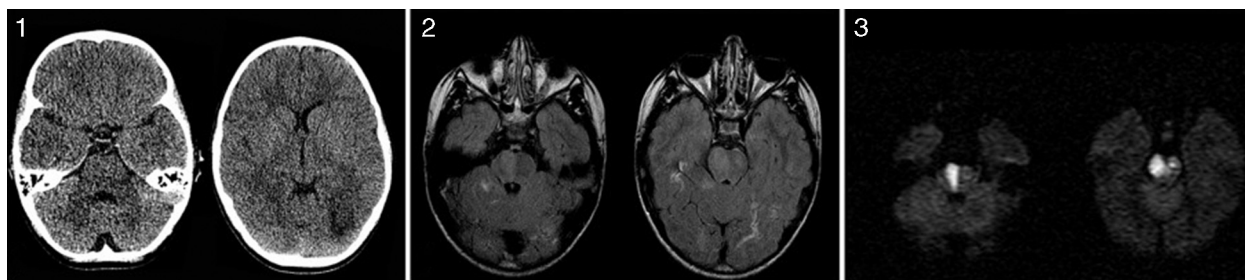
(1) An emergency low-dose CT scan shows a small hypodense occipital subcortical lesion adjacent to the occipital horn of the left lateral ventricle, with no other relevant findings. (2) Brain MRI scan: an axial FLAIR sequence reveals hyperintense lesions compatible with ischaemic lesions on the pons and in white matter of the temporal and occipital lobes. (3) An axial DWI sequence ($b = 1000 \text{ s/mm}^2$) confirmed the presence of an acute ischaemic lesion on the pons, with markedly restricted diffusion. The left occipital and right temporal lesions are not hyperintense in the DWI sequence due to a longer progression time.
